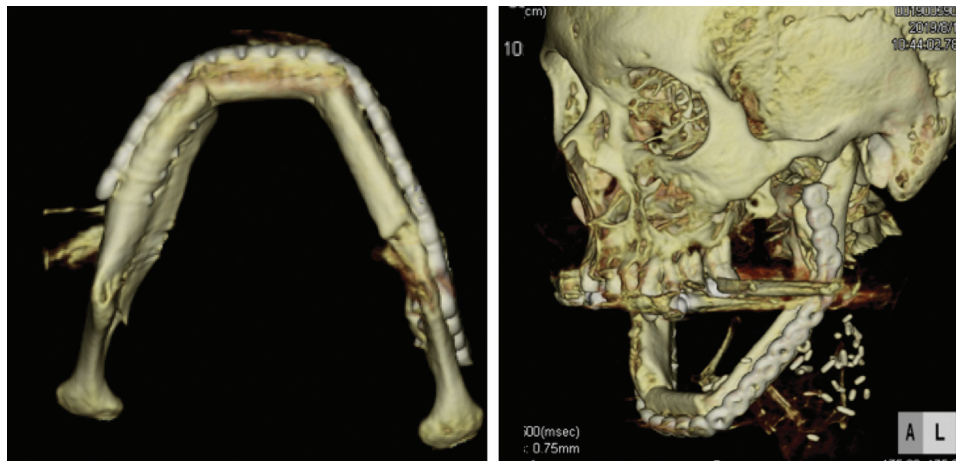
The computed tomography images at 6 months after reconstruction of the mandible.
